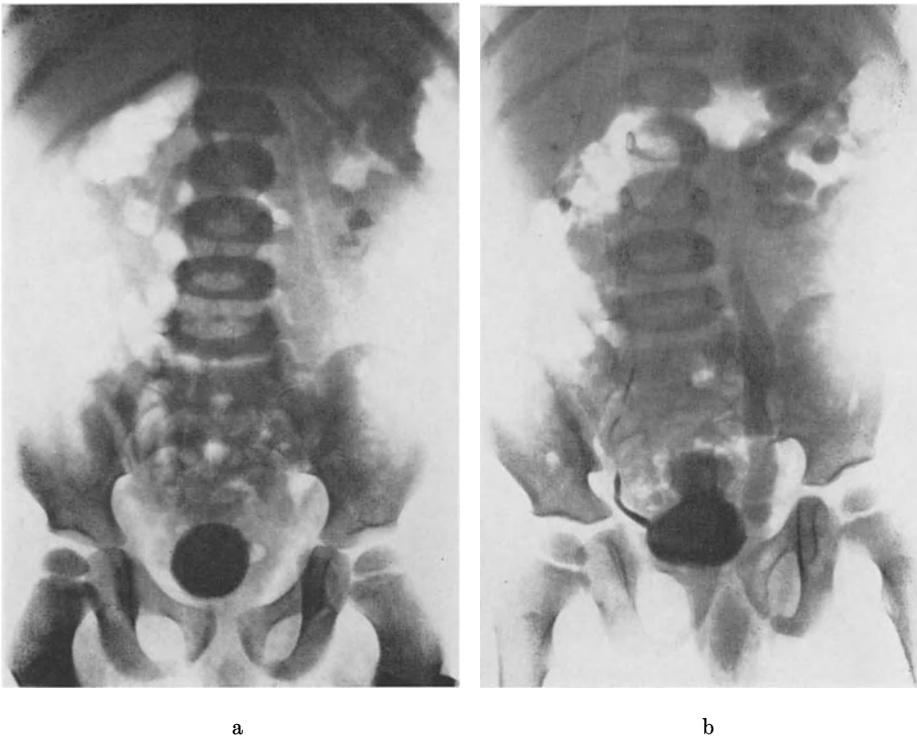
Renal and vesical calculi. Boy with dysuria and *Proteus* infection. a Straight X-ray showing left renal and vesical calculi. b Intravenous urogram showing normal right kidney and dilated left ureter; reflux present
